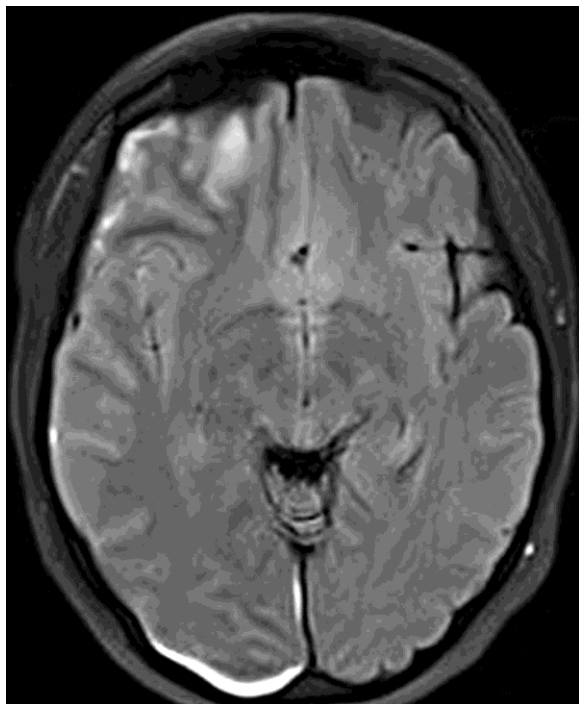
The patient's follow-up CT scan of the brain, axial plane view, showing a mild left midline shift and development of frontal infarct with stable right subdural hematoma.
